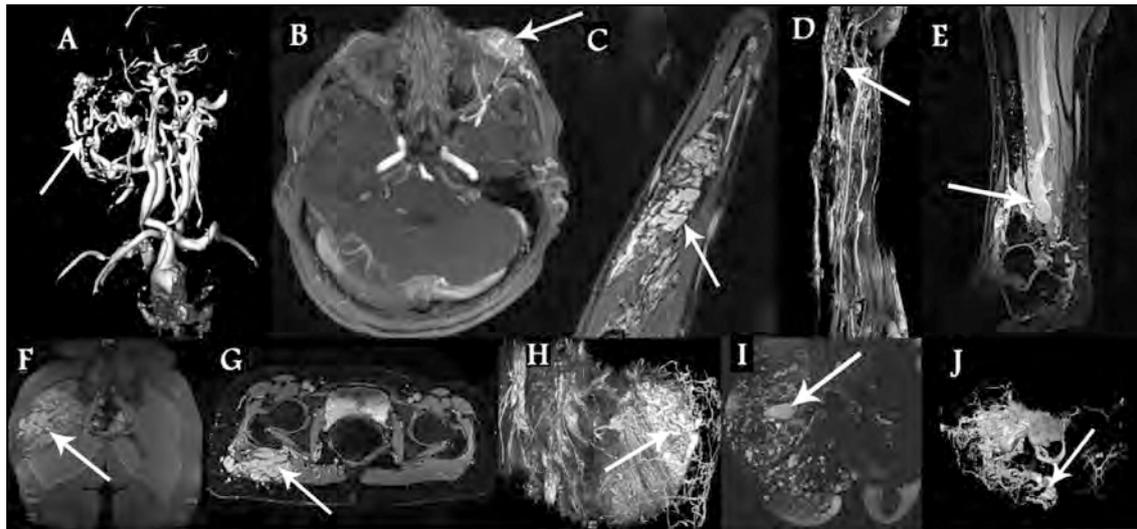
Presentation of arteriovenous malformations with foci of abnormal vasculature on magnetic resonance imaging studies A and B, head and neck; C and D, upper extremities; E, lower extremity; F–J, gluteal and pelvic regions
